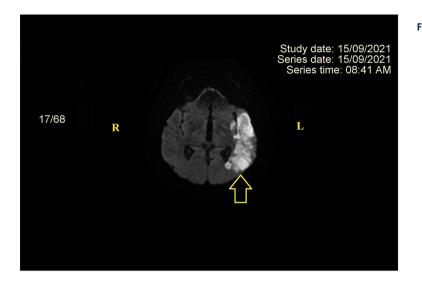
MRI in DWI. Recent ischemic stroke in superficial left MCA (indicated by yellow arrow). The image was acquired using GE SIGNA EXPLORER 1.5T magnetic resonance imaging device produced by General Electric Healthcare Japan Corporation – Japan. MRI – magnetic resonance imaging; DWI – diffusion-weighted imaging; R – right; L – left.
